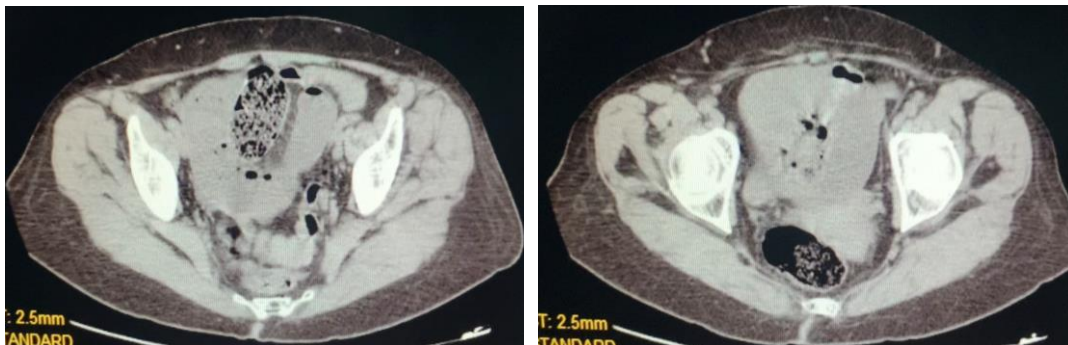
CT scan showing a loop incarcerated in an internal hernia
